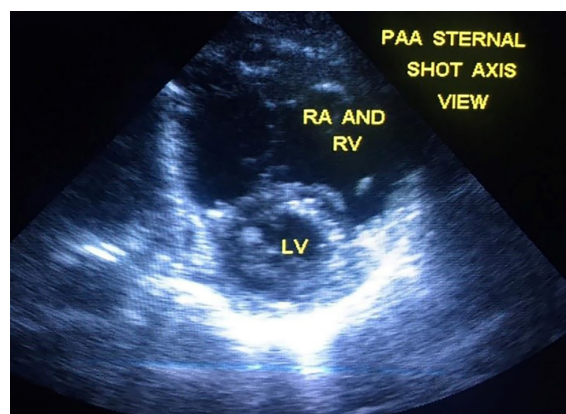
Parasternal short-axis view revealed Right Ventricular Enlargement in Ebstein anomaly
